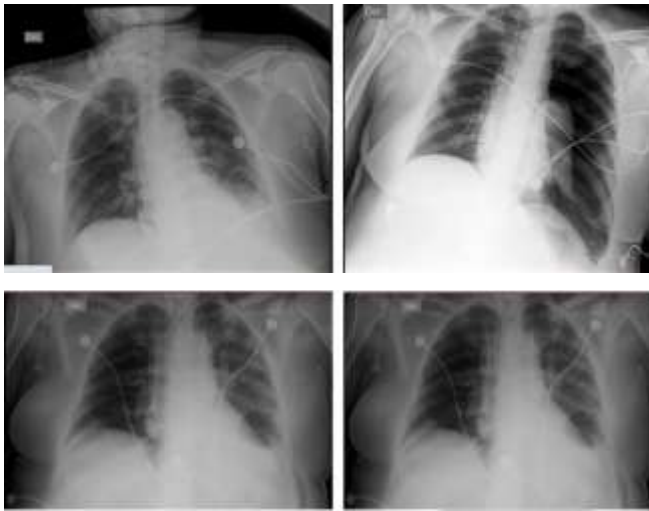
Serial chest radiographs demonstrating the patient's radiographic pulmonary progression. (On admission) showed preserved pulmonary parenchymal integrity without evidence of acute pulmonary pathology. (Day 3) imaging revealed a massive left-sided pneumothorax involving approximately 50-70% of the lung volume with mild rightward mediastinal shift. (Day 3 left down) A subsequent radiograph obtained after chest tube insertion on the same day demonstrated initial lung re-expansion and correct positioning of the left thoracostomy tube with residual atelectatic changes following re-expansion. (Day 4) Complete re-expansion on the left lung was observed with the left-sided chest tube remaining in place and no evidence of recurrent pneumothorax.
